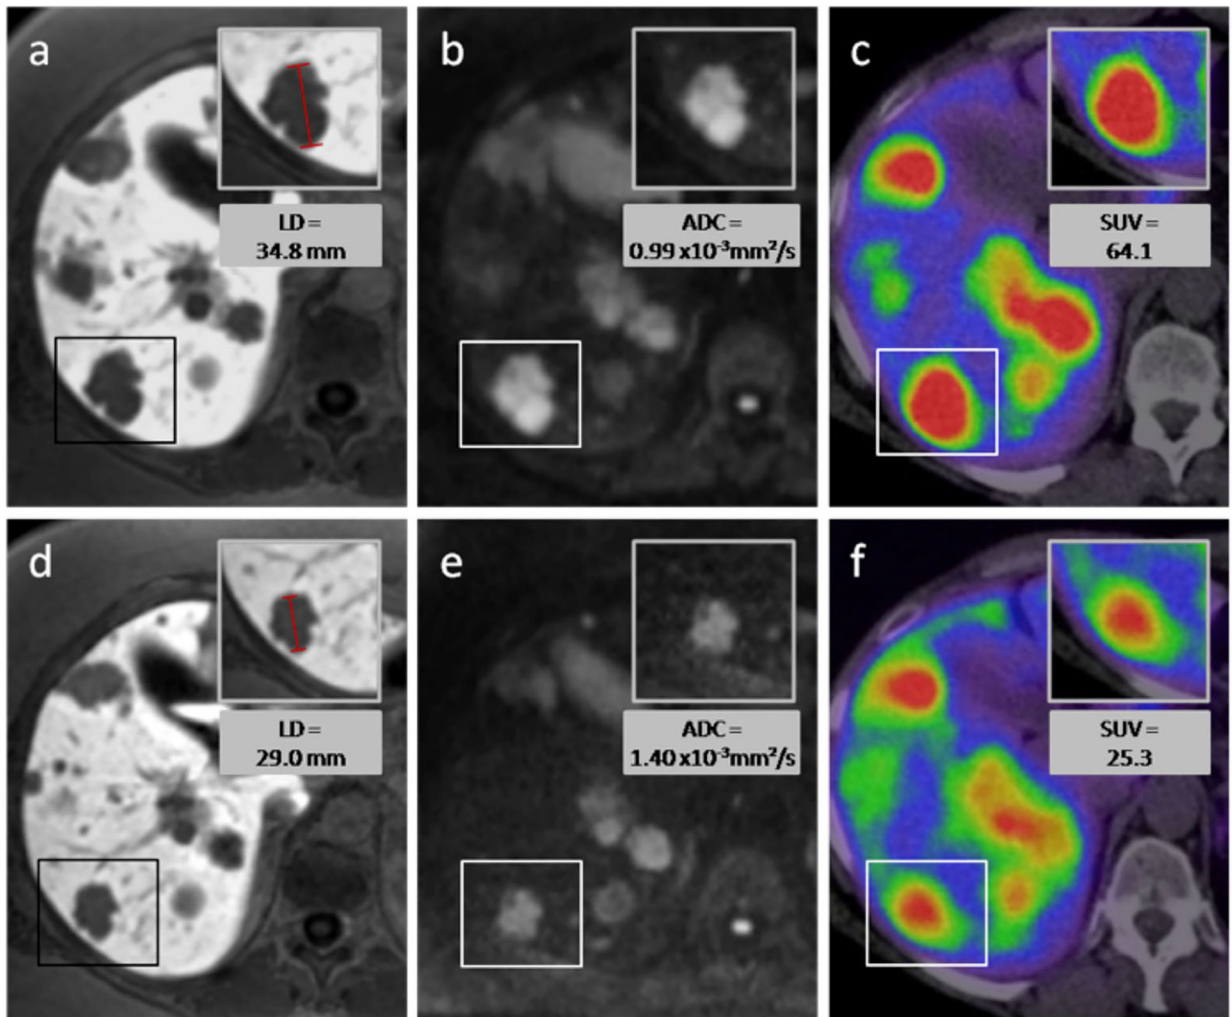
Responding lesion—a 54-year-old female with hepatic metastases from a pancreatic NET. After two cycles of intraarterial PRRT with 4 GBq ^{90}Y - and ^{177}Lu -DOTATOC, the longest diameter of the target lesion (*box*) decreased as can be seen on MR images with the hepatocyte-specific contrast agent Gd-EOB-DTPA (a, d). The volume of the lesion decreased from 11.0 to 5.0 cm³. On diffusion-weighted MRI (b, e) an increase of ADC_{mean} from 0.99×10 to 1.40×10^{-3} mm²/s was measured, while the SUV_{max} on ^{68}Ga -DOTATOC-PET/CT decreased from 64.0 to 25.3. *Upper row of figures* images before PRRT, *lower row* images after PRRT.
